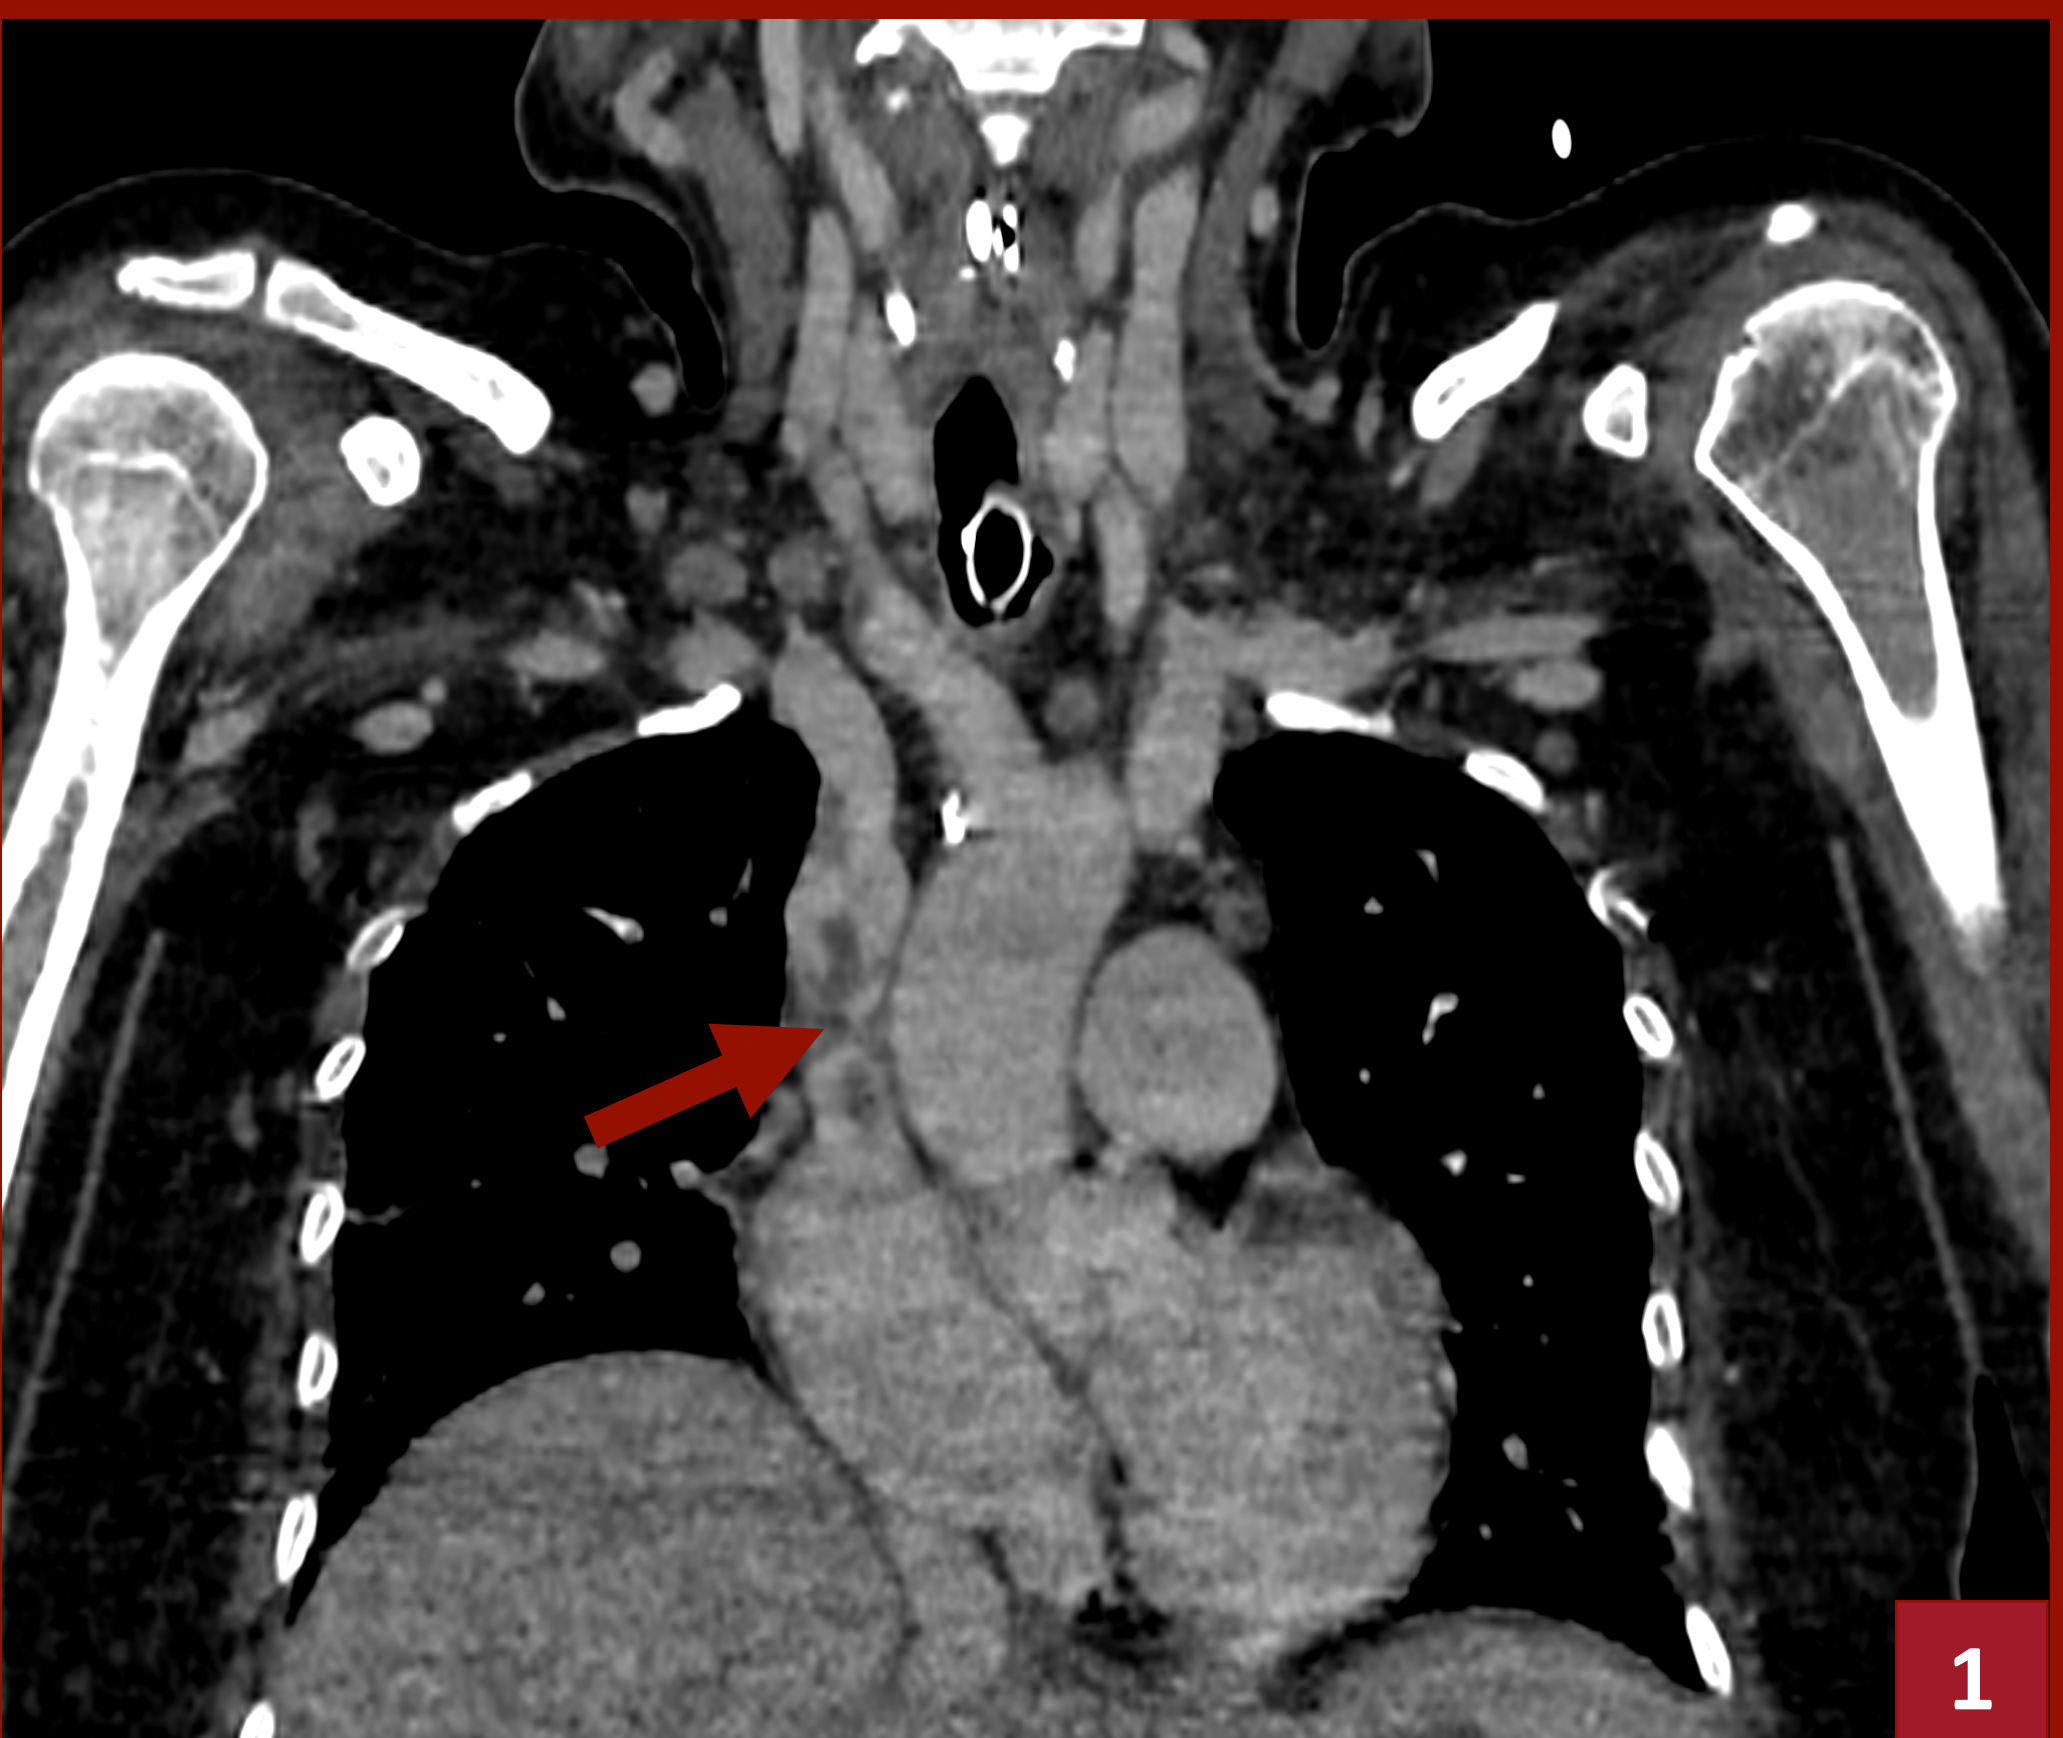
Coronal CT: Thrombosis of the bilateral internal jugular and brachiocephalic veins with extension into the superior vena cava.
